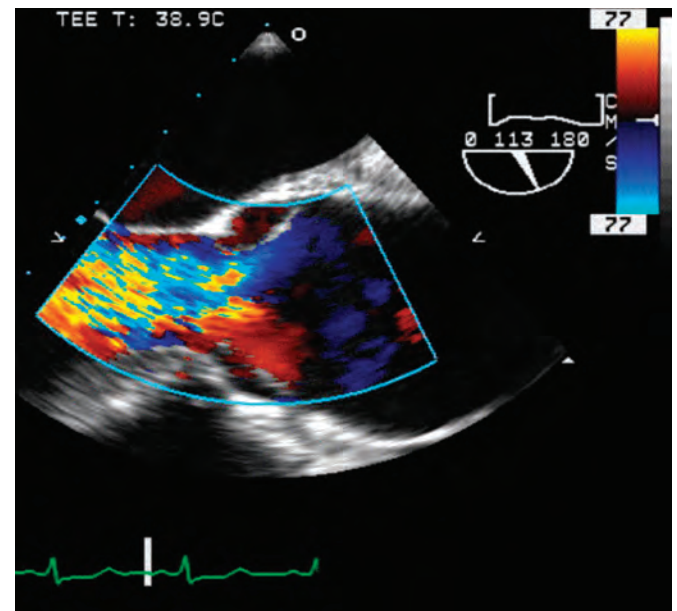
Midesophageal long-axis view of the aortic valve and ascending aorta in systole before cardiopulmonary bypass (at 113 degrees of rotation). Color-flow Doppler interrogation reveals severe aortic regurgitation, as the diastolic jet visualized by color Doppler imaging fills the entire left ventricular outflow tract. The mechanisms of this severe aortic regurgitation, namely, intimal prolapse and aortic root dilation, are more fully explained in Figs. 23.41 and 23.42.
